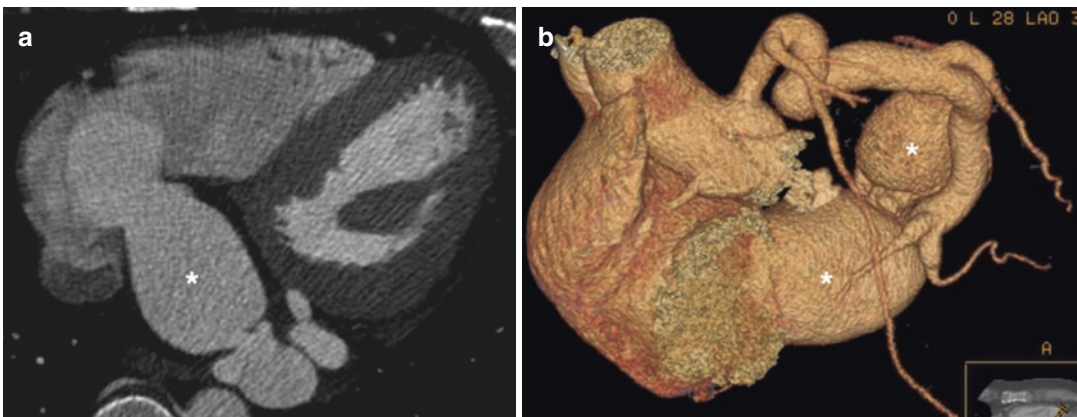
Left circumflex artery to coronary sinus fistula. (a) Gated axial CT image demonstrating a very dilated coronary sinus (asterisk) draining into the right atrium. (b)
